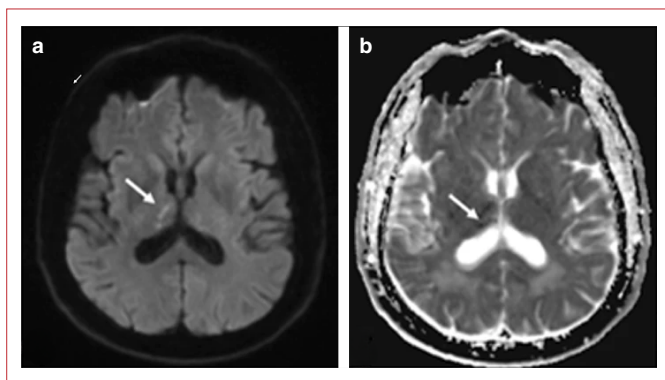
Diffusion-weighted magnetic resonance imaging (MRI) scan. (a) Right and left thalamic cytotoxic edema is observed as diffusion restriction in a linear pattern (arrow). (b) Apparent diffusion coefficient (ADC) maps show ADC hypointensity confirming right thalamic cytotoxic edema (arrow).
